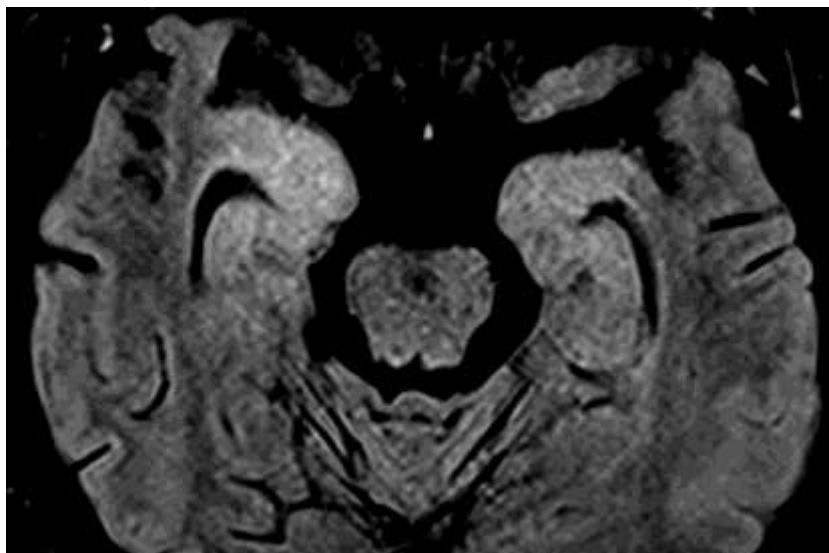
Axial FLAIR image shows autoimmune limbic encephalitis
